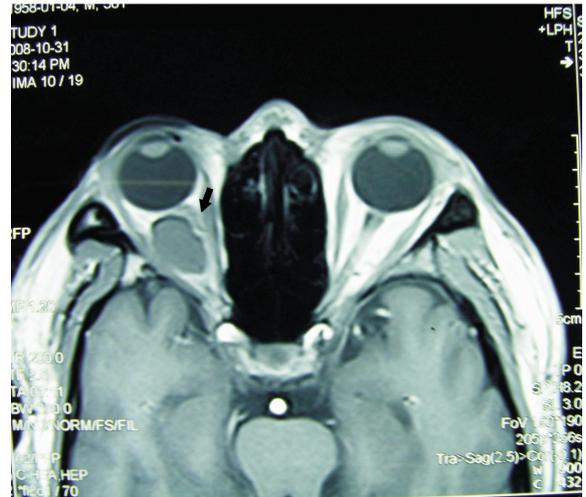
Distorted and irregular optic nerve (black arrow) revealed by axial MRI in case 1 with severe adhesion
